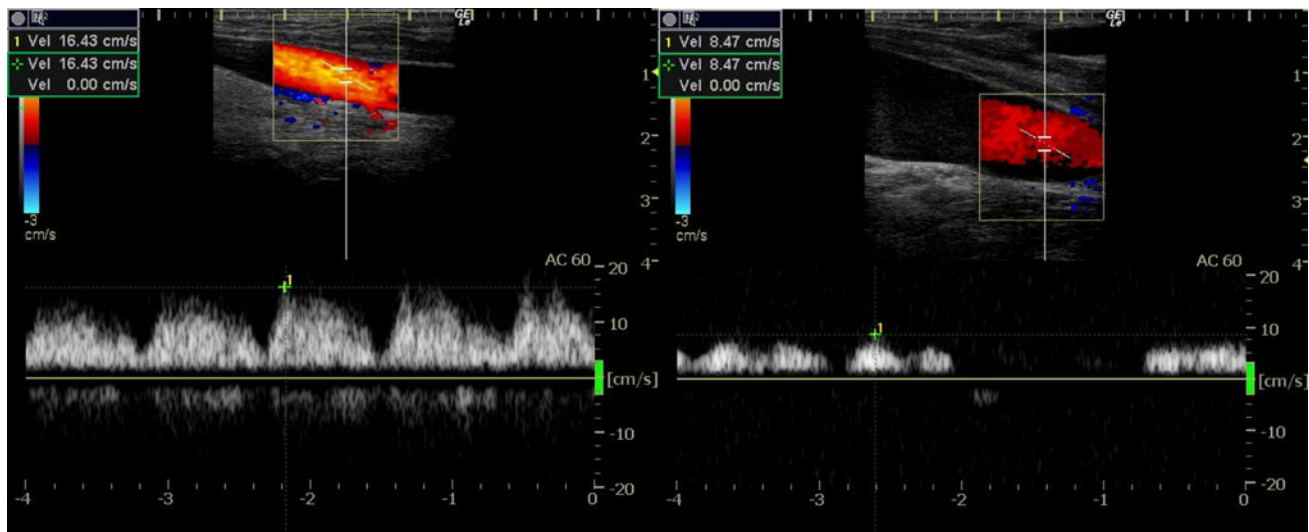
Left* internal jugular venous-flow velocity of this patient in the supine position. *Right* venous flow velocity in the prone position. Ultrasound examination was performed during the second repair surgery. Velocity is decreased by half in the prone position
